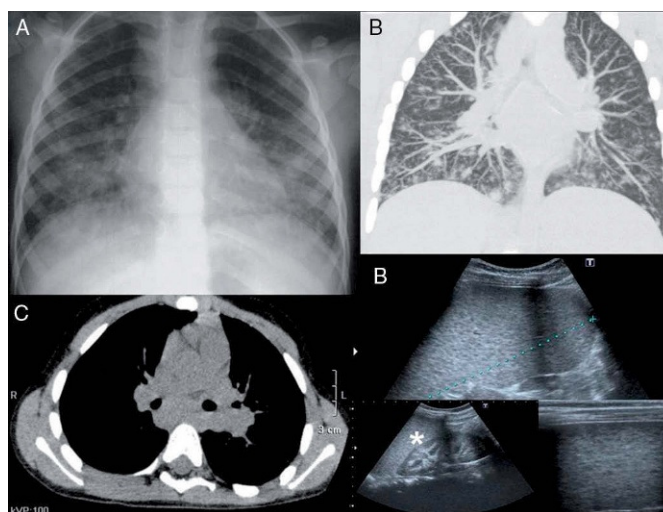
A. Chest x-ray, widening of the paratracheal stripes and increase in hilar size secondary to the presence of adenopathies. Undefined increase of bilateral basal density, with a tendency towards confluence, associated with small nodular images. B. Chest CT scan, ground-glass nodular opacities and well-defined nodules with diffuse distribution. Thickening of the interlobular septa. C. Chest CT scan, hilar and subcarinal adenopathies. D. Abdominal ultrasound, splenomegaly with the presence of a multitude of small focal hypoechoic lesions due to the presence of granulomas. Increased renal pyramid echogenicity, caused by calcium deposits and nephrocalcinosis
